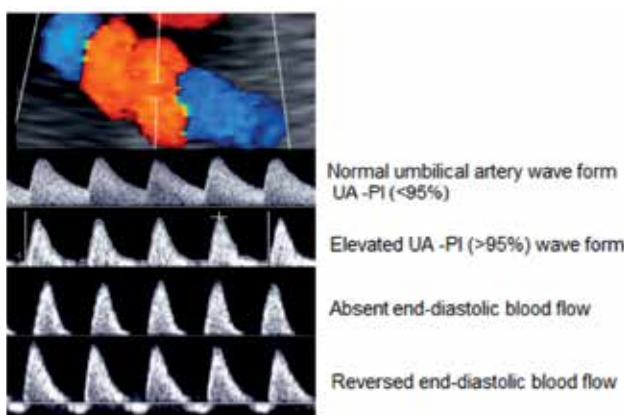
Umbilical artery Doppler evaluation.
